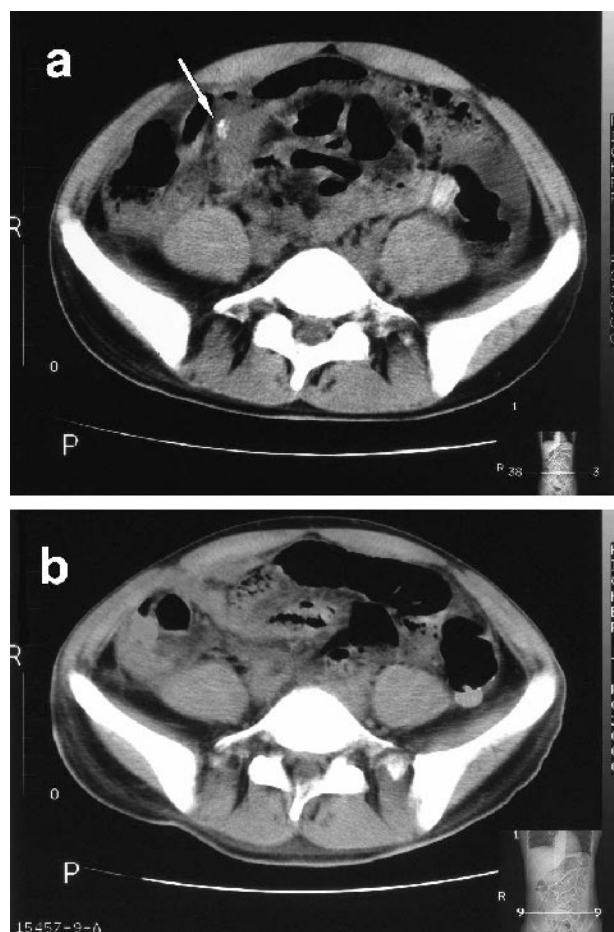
a. Abdominal CT scan showing fluid collection in the right lower quadrant containing an opaque fecalith (arrow). b. Repeat CT scan showing absence of the opacity the next day following relaparoscopy to remove the fecalith.
